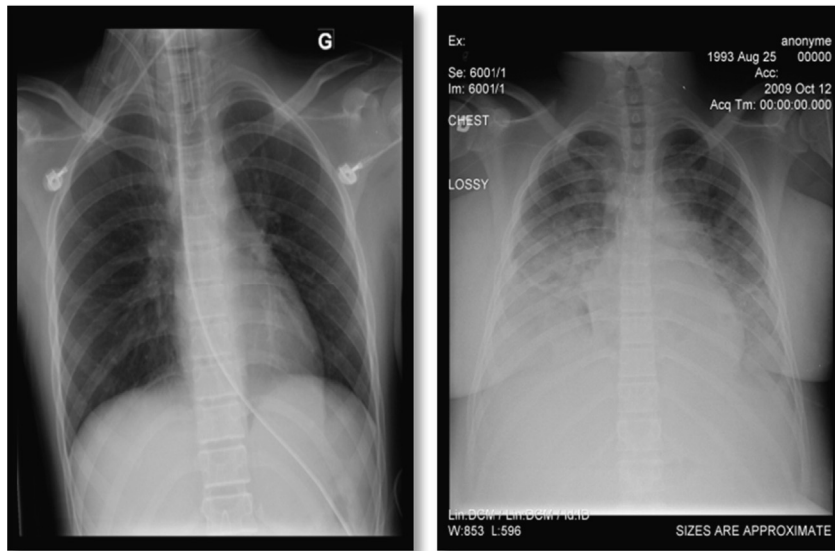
Left chest radiograph: normal case; right chest radiograph: ARDS case (Ref: Sainte Justine Hospital).
